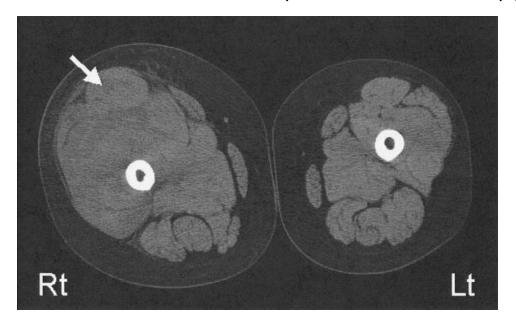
Computed tomography scanning of bilateral thighs on admission. Right (Rt) and left (Lt) quadriceps muscles are indicated. Arrow indicates the presence of hematoma. Circumferences of the right and left thighs were 55.0 and 50.5 cm, respectively.
